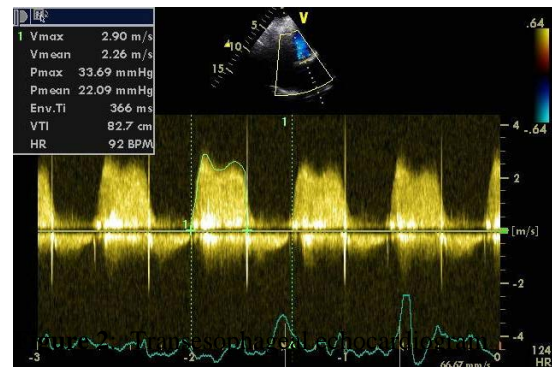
Transesophageal echocardiogram
